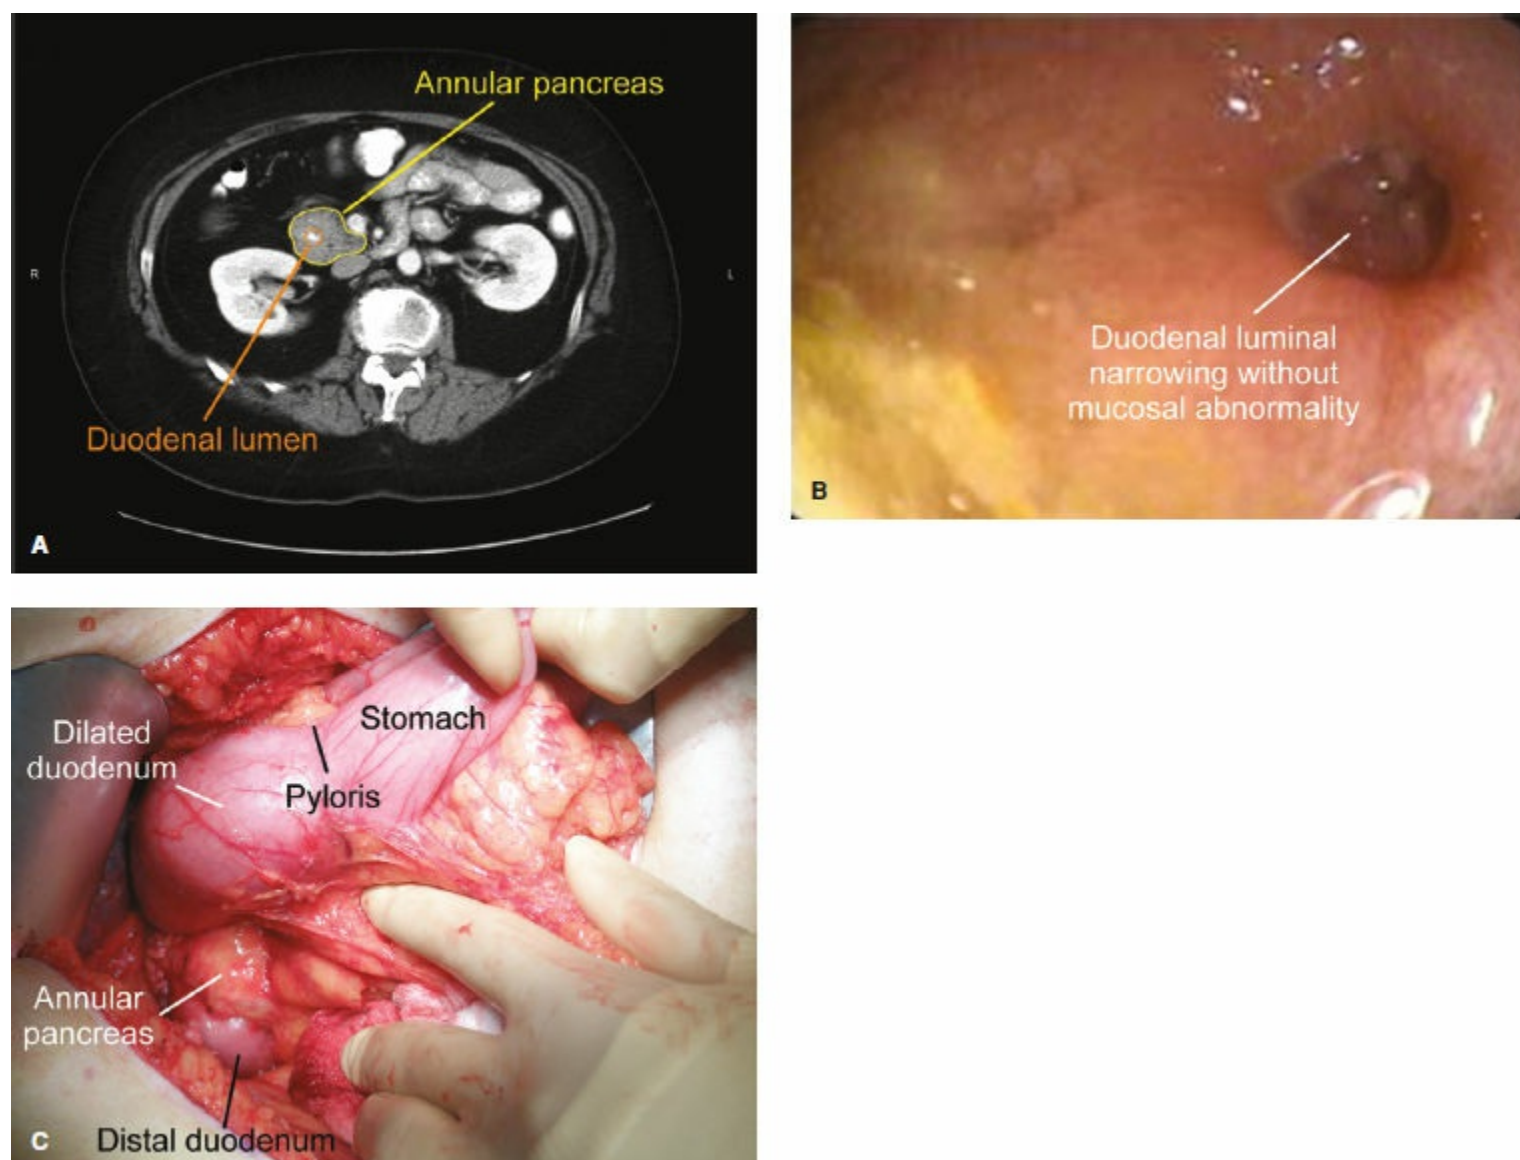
Annular pancreas. A: CT scan of a patient with annular pancreas. There is a ring of pancreatic tissue surrounding the duodenum, with a narrowed duodenal lumen. B: EGD image in the same patient. Note narrowing of the duodenal lumen with no mucosal lesion consistent with external compression by the annular pancreas. C: Intraoperative photo of an annular pancreas. Note the dilated duodenum after the pylorus, the ring of pancreatic tissue surrounding the duodenum just distal to the dilation, and the decompressed distal duodenum.
